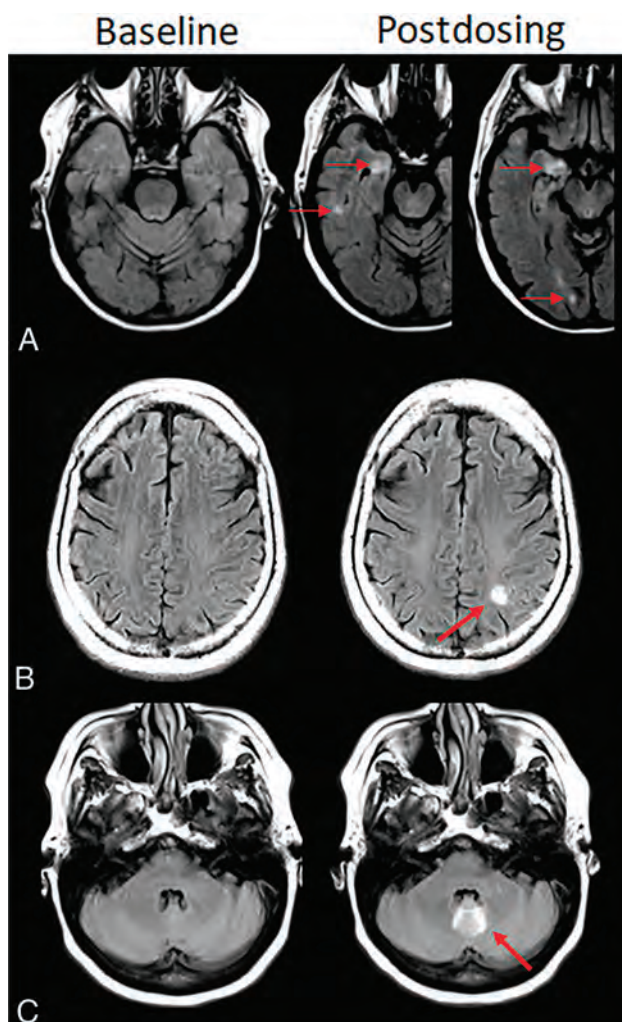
Atypical ARIA-E, parenchymal edema. Axial T2-FLAIR images from 3 separate patients at pretreatment baseline (*left*) and on a monitoring examination following initiation of anti-amyloid monoclonal antibody therapy (postdosing, *right*). *A*, Adjacent slices on postdosing T2-FLAIR show development of multiple nodular areas of ARIA-E (*red arrows*). This nodular presentation is less commonly encountered in contrast to the typical ARIA-E, which has an amorphous parenchymal pattern as expected for vasogenic edema. In this case, although each area of ARIA-E is small (<5 cm), the multiplicity of lesions yields a classification of moderate ARIA-E. *B*, Atypical ARIA-E as a rounded focus of T2-FLAIR hyperintense signal in the left parietal white matter (*left, red arrow*) that may be mistaken for neoplastic process and differentiated by the time course of appearance coinciding with monoclonal antibody dosing and subsequent resolution. *C*, Atypical ARIA-E in the cerebellar vermis. Postdosing, new T2-FLAIR hyperintense signal in the cerebellar vermis (*red arrow*), a less common location for ARIA-E relative to the cerebral hemispheres. Although ARIA-E has a slight predilection for the parieto-occipital lobes, similar to posterior reversible encephalopathy, any part of the brain may be affected. Images courtesy of Biogen and the Dominantly Inherited Alzheimer Network.
